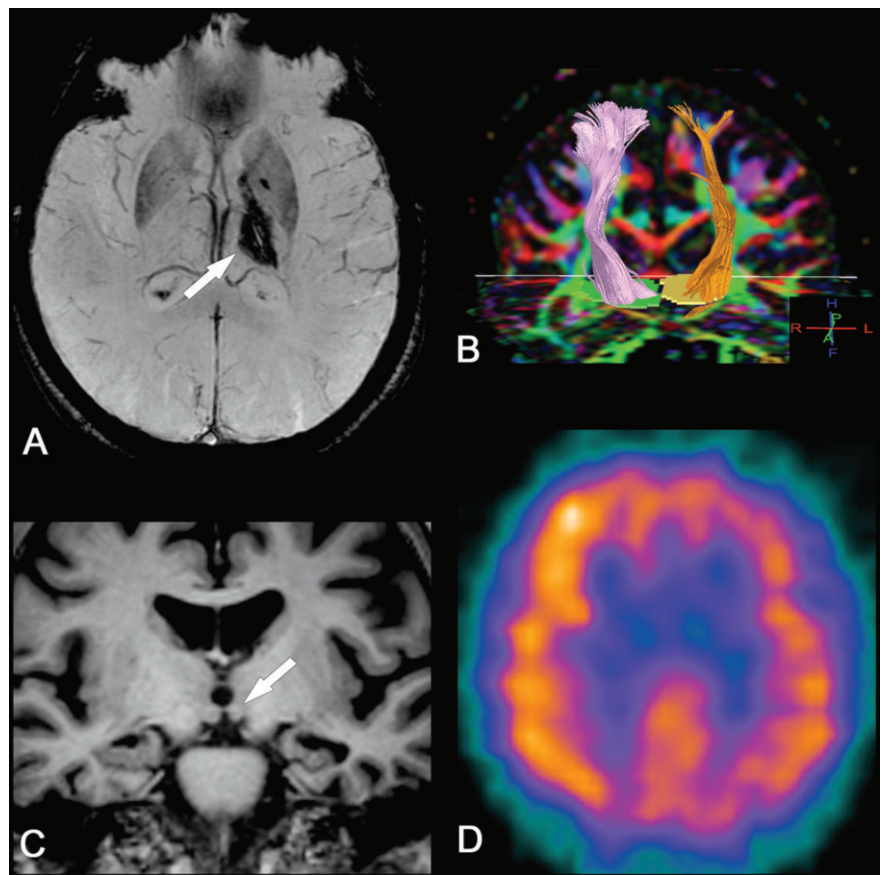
Axial susceptibility-weighted image (A) discloses the old thalamic hemorrhage as diffuse hypointensity (arrow). Tractography obtained by placing seeds in the thalamus and the corresponding parietal lobe on each side, encompassing predominantly the posterior thalamic radiations, shows asymmetry, with decreased fibers on the left (dark orange) compared to the right (light purple) (B). Coronal T1-weighted inversion-recovery image (C) demonstrates the atrophy of the left mammillary body (arrow). 99mTc-HMPAO SPECT axial image (D) shows hypoperfusion in the left frontal and parietal cortices.
